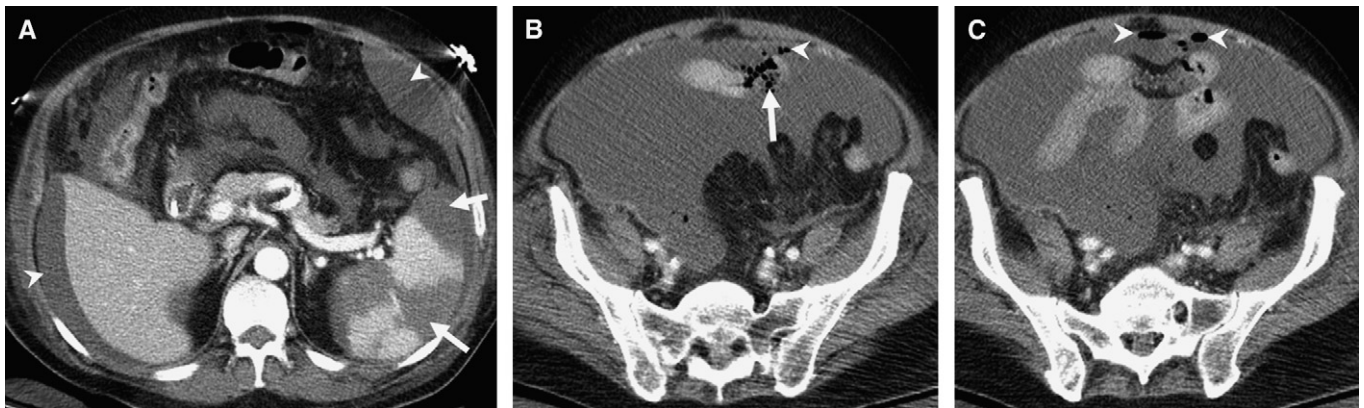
Splenic lacerations and ileal perforation in a 66-year-old woman involved in a motor vehicle injury. (A) Axial contrast-enhanced computed tomography (CT), revealing multiple large splenic lacerations (arrows) with hemoperitoneum (arrowheads). (B, C) Caudal CT sections, revealing an ileal loop perforation (arrow in B) with free extraluminal air (arrowhead in C). There is a large hemoperitoneum.
